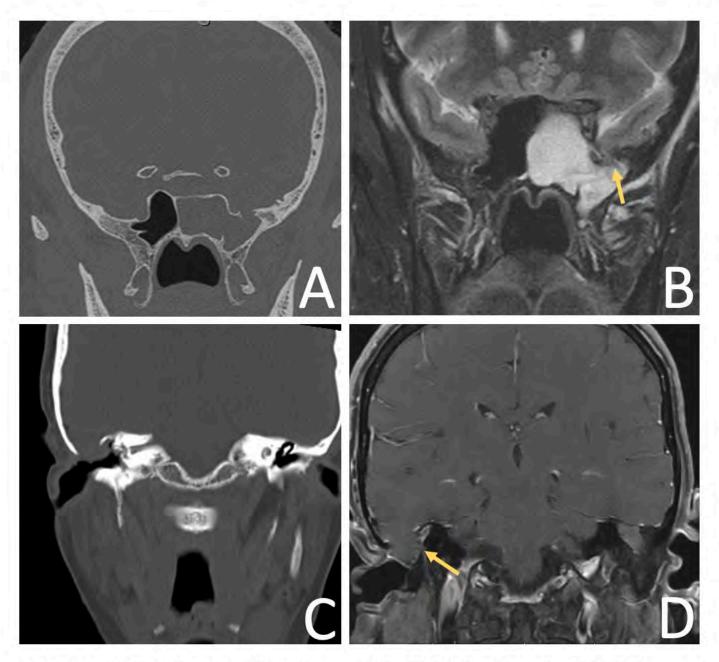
For Case 1, CT sinus without contrast (A) demonstrates opacification of the left sphenoid sinus and a small defect in the sphenoid roof. Same day MR stir sequence of the facial bones (B) demonstrates a 6mm defect in the sphenoid roof with an inferiorly herniated encephalocele (arrow) with hyperintense fluid opacifying the left sphenoid sinus. In Case 2, CT Temporal bone without contrast (C) shows a large anterior tegmen mastoideum defect. An MR brain T1 sequence (D) of the same patient demonstrates a right inferior temporal gyrus encephalocele herniating through the defect (arrow).
